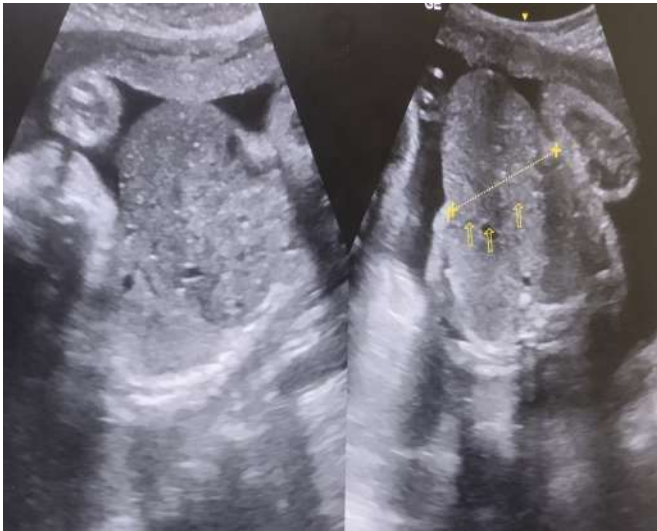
Membrane-covered liver-containing omphalocele. Prenatal ultrasonographic image demonstrating a midline anterior abdominal wall defect with herniation of abdominal contents, including the liver, into a membrane-covered sac (yellow arrows), consistent with an omphalocele. The maximal sac diameter measured approximately 4.5 cm.
